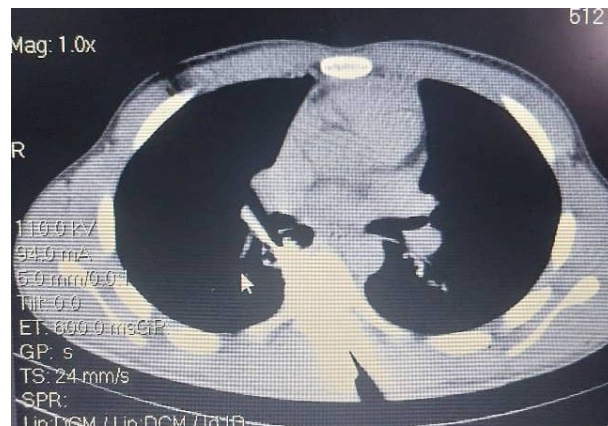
CT scan axial cut showing tip of the knife penetrating the body of T5 vertebra obliquely entering the right lung parenchyma.
